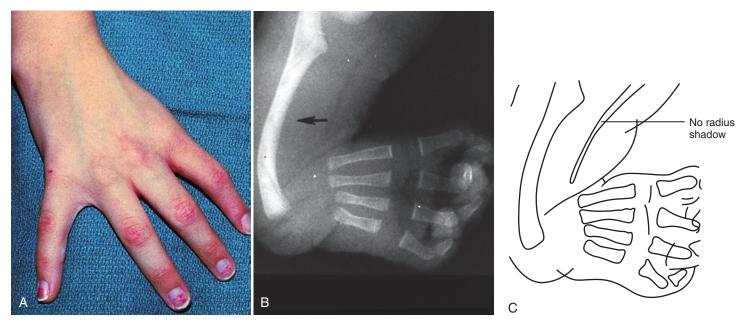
Holt-Oram syndrome. Note the absence of the radius and thumb (A). The associated cardiovascular abnormality is an atrial septal defect. Radiographic examination (B and C) demonstrates the absence of a radius shadow; the missing thumb is apparent.
